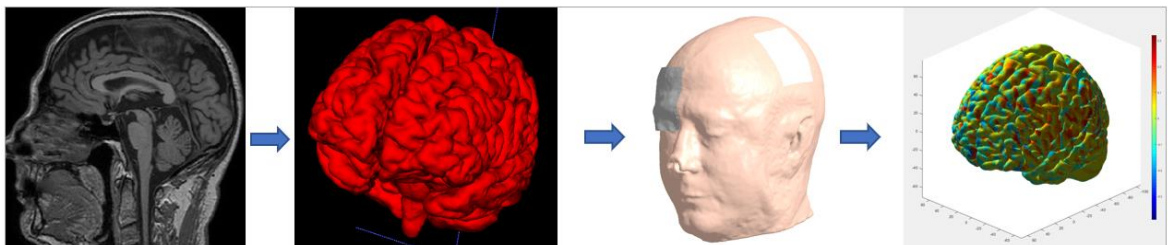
Different steps followed, from the MRI acquisition up to the calculation of the E-field (in the last image, the distribution over a concert montage done in this project can be seen, units in (V/m)).
